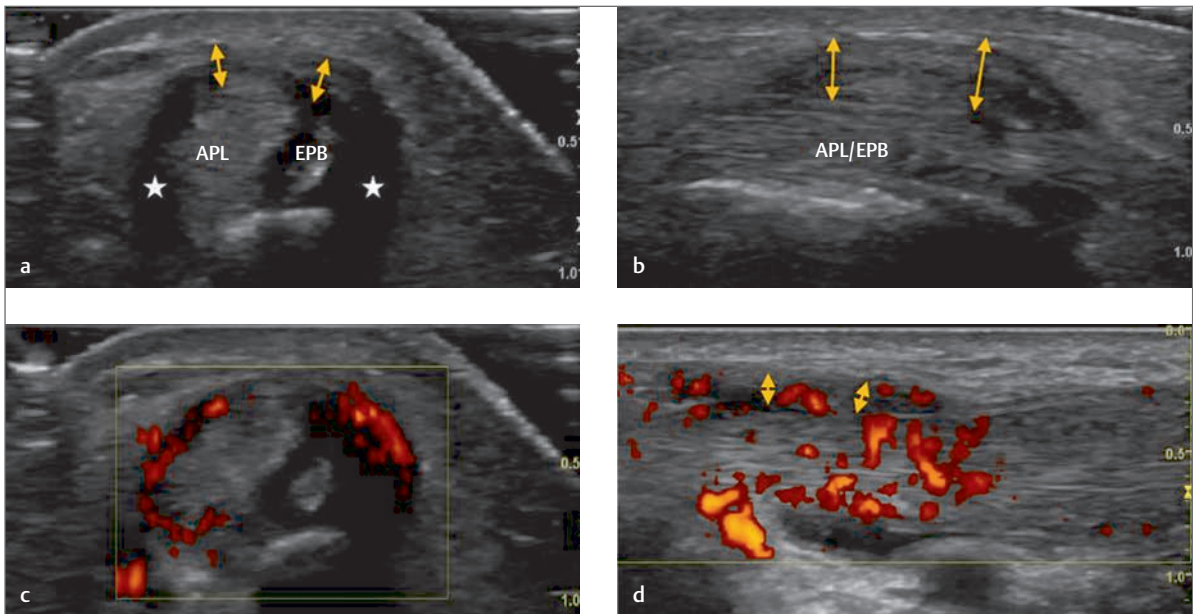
(a) Transverse image of the first dorsal compartment. The tendons of abductor pollicis longus (APL) and extensor pollicis brevis (EPB) appear intact. However, fluid is noted around the tendons (white stars) and the extensor retinaculum appears thickened (double-headed yellow arrows). (b) Longitudinal image demonstrating the marked thickening of the extensor retinaculum more clearly (double-headed yellow arrows). (c) In addition to fluid within the first dorsal compartment and thickening of the retinaculum, Power Doppler demonstrates a significant tenosynovitis around the tendons within the tendon sheath. (d) Longitudinal image with Power Doppler demonstrating tenosynovitis within the tendon sheath at the level of the extensor retinaculum (double-headed yellow arrows).
